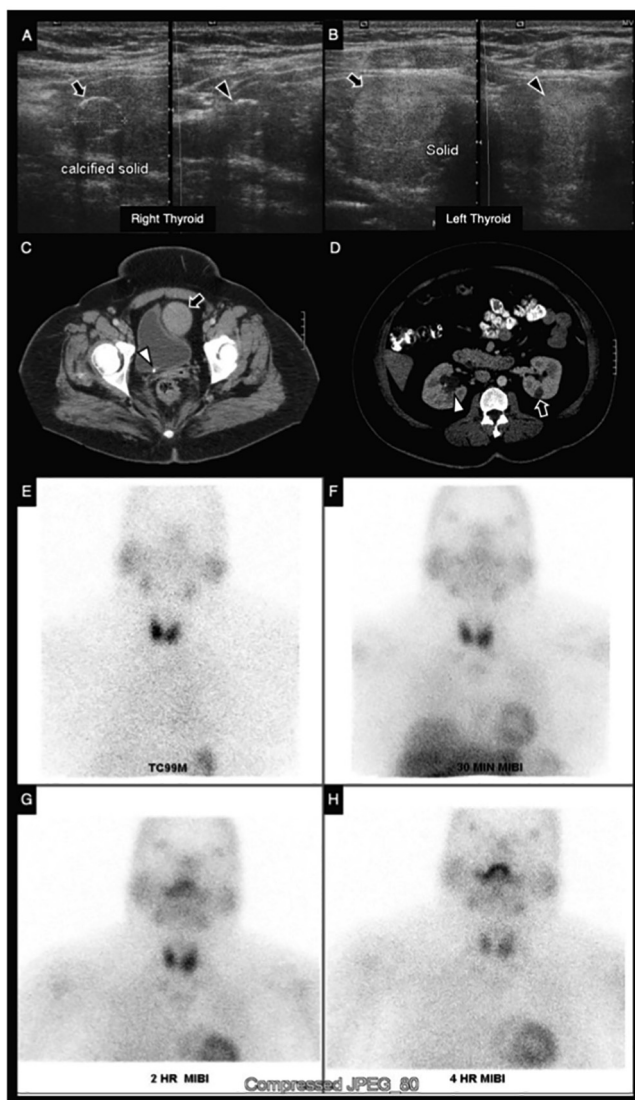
Pertinent radiologic imaging of the case. The right lobe of the thyroid gland showed solid nodules with rim calcifications measuring $1.1 \times 0.9 \times 0.9$ cm at the upper third (A; arrow) and $0.4 \times 0.5 \times 0.4$ cm at the lower third (A; arrowhead). The left lobe of the thyroid glands displayed solid nodules measuring $2.2 \times 1.6 \times 1.6$ cm at the middle third (B; arrow) and $1.1 \times 0.7 \times 0.8$ cm at the lower third (B; arrowhead). Axial view of the abdominal CT scan demonstrated an enlarged uterus with a knobby outline suggestive of myoma formation (C; arrow), a right ureterovesical junction lithiasis (C; arrowhead), a left renal cyst (D; arrow) and mild hydronephrosis on the right (D; arrowhead). Parathyroid imaging with technetium 99 m (Tc99m) sestamibi (MIBI) scintigraphy showed normal imaging.
